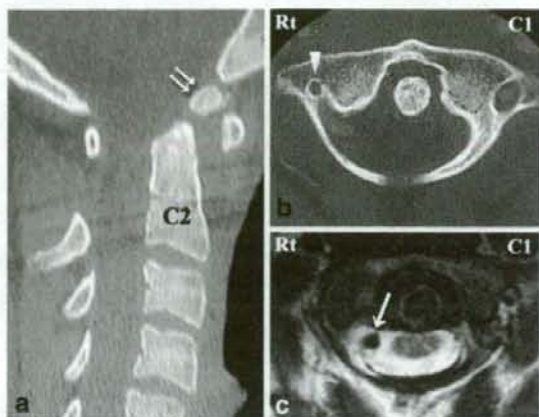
Preoperative imaging in patient 5. a Midsagittal reconstructed image from the CT scan reveals an os odontoideum (double arrows). b Axial CTA image at the C1 level shows that the transverse foramen is smaller on the right (arrowhead) than on the left. c Axial T2-weighted MR image at the C1 level shows a circular flow-void shadow in the spinal canal (arrow)
